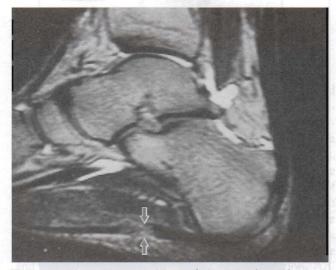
In this sagittal MRI of the right foot of a male college student basketball player, increased signal intensity and discontinuity of the plantar fascia (*arrows*) are consistent with edema, hemorrhage, and complete rupture. (Courtesy of the Radiology Department of the Medical College of Ohio at Toledo. From Kruse RJ: Diagnosing plantar fasciitis. Physician Sports Med 23[1]:117–126, 1995.)
